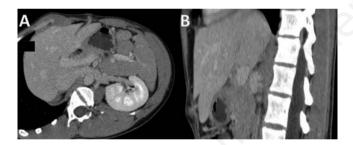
Oblique axial (A) and oblique sagittal (B) abdominal contrast enhanced computed tomography scan.
